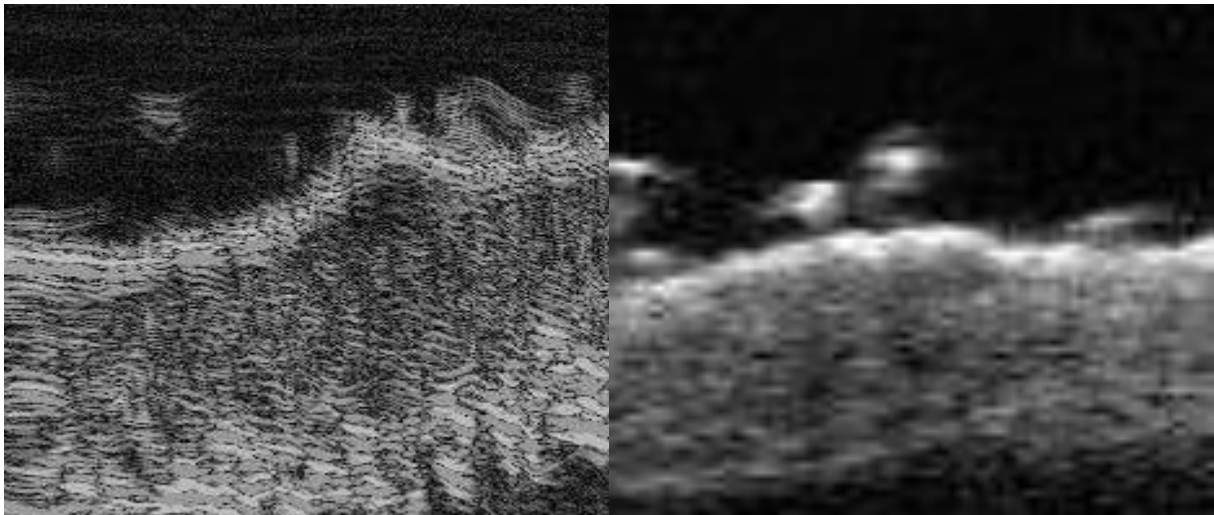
Ultrasound images of a nevus. Left: imaged using our own UltraDerm device. Right: imaged using a competitor (Draminski/Interson). Work with Gergely Csány and Helga Feiszthuber.*
